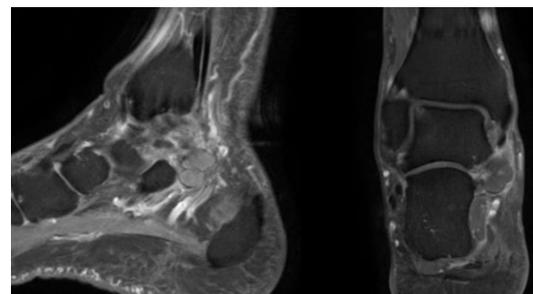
T2 MRI sagittal and coronal views suggestive of a ganglion cyst in the tarsal tunnel, arising from the subtalar joint.
